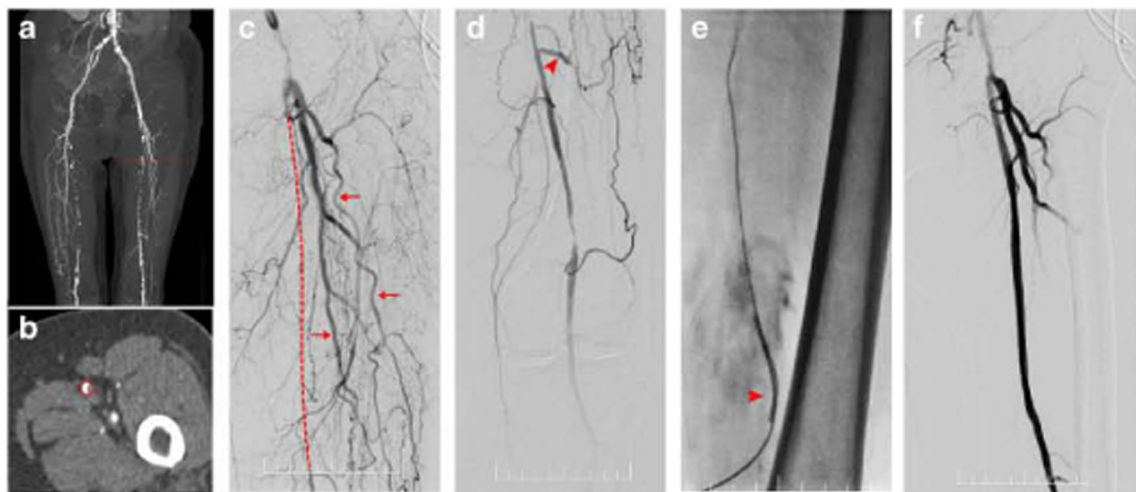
Retrograde recanalisation of a left superficial femoral artery (SFA) chronic total occlusion (CTO). A 71-year-old woman with an 8-year history of diabetes suffered severe claudication for 15 months. Lower limb CT angiography (CTA) showed long-segment occlusion in the left
